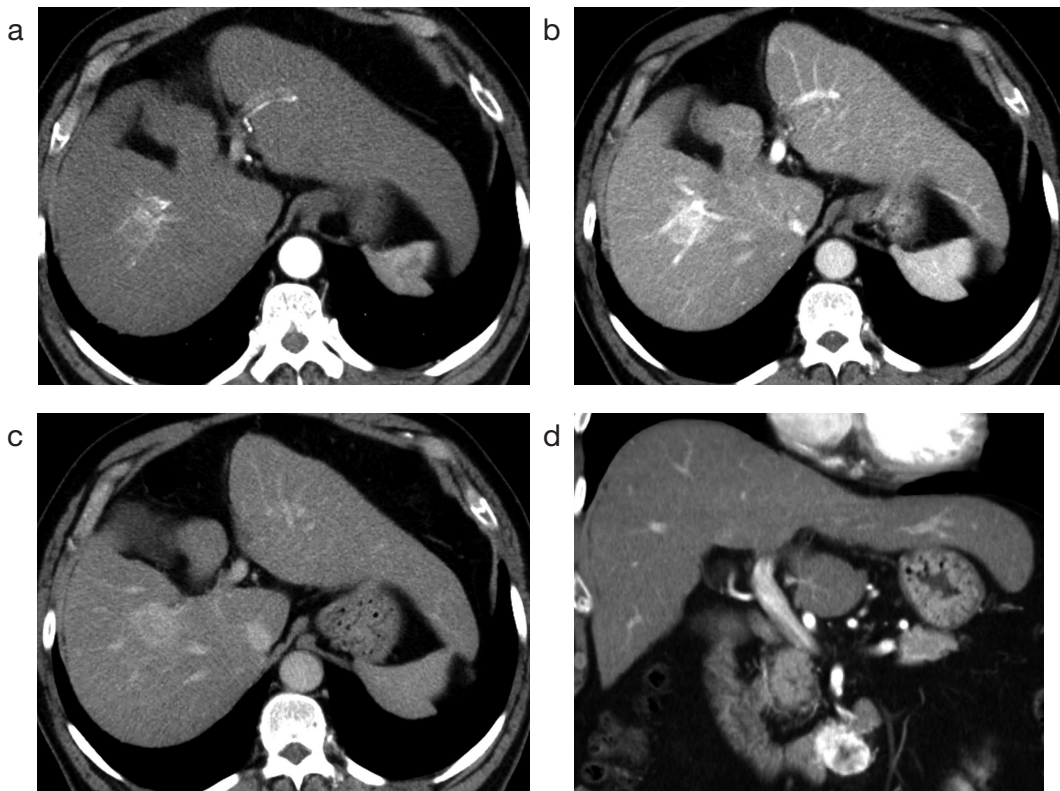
Contrast-enhanced CT images
